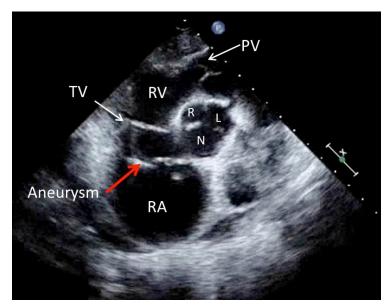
Transthoracic echocardiogram: 2D parasternal short-axis view at the level of the aortic valve showing an aneurysm originating from the non-coronary sinus of Valsalva and protruding into the right atrium at the level of the tricuspid valve. RA-right atrium, RV-right ventricle, TV-tricuspid valve, PV-pulmonary valve, R, L, & N-right, left, and non-coronary aortic cusps.
